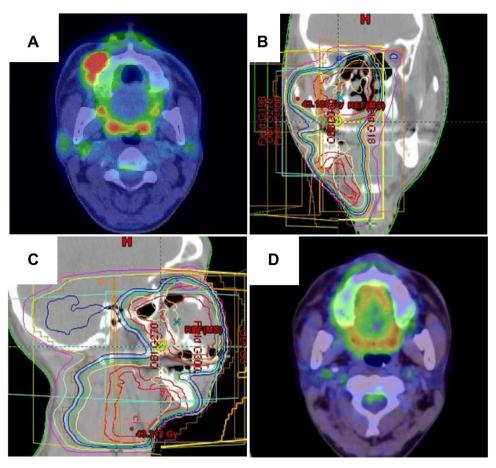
(A) PET-CT image before chemoradiotherapy (B)(C) CT images of irradiation field. The right upper first premolar was included in the radiation field and irradiated with 43 Gy. (D) PET-CT image after chemoradiotherapy in September 2014.
